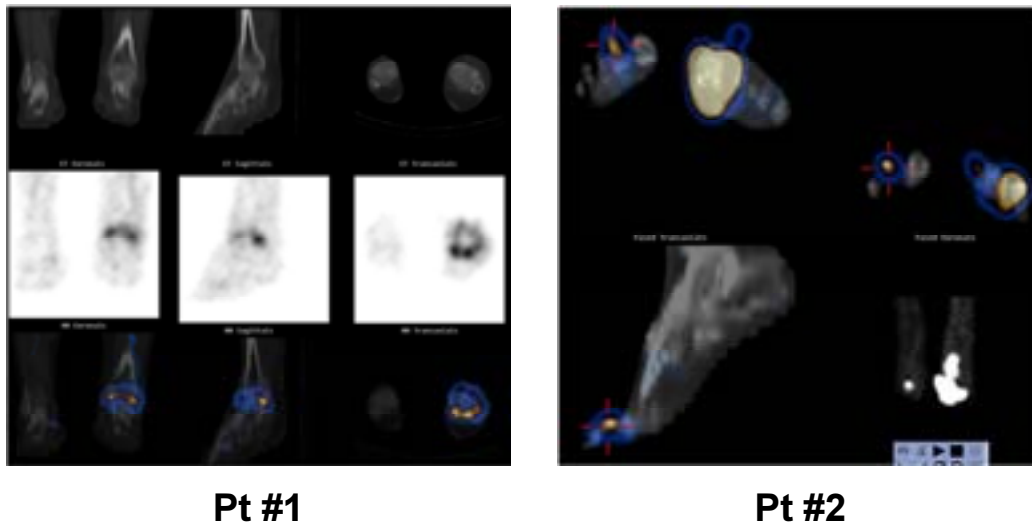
Patients with different forms of osteomyelitis, with accurate definition of the extent of infection by SPECT/CT. Post-traumatic osteomyelitis of the left ankle in Pt #1 (left panel), imaged after injection of ^{99m}Tc -anti-granulocyte antibody. In Pt #2 (right panel) SPECT/CT performed during autologous ^{99m}Tc -HMPAO-leukocyte scintigraphy demonstrates that infection arising in a diabetic foot involves not only the soft tissue but also bone structures. Such accurate localization of the disease process was problematic not only on planar scintigraphy but also on stand-alone SPECT.
